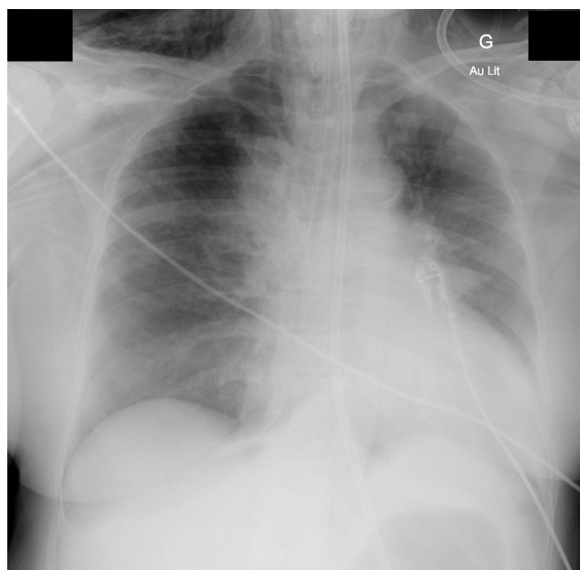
Initial chest radiography. Note the presence of cervical subcutaneous emphysema and bilateral muscular emphysema in the pectoralis major.
